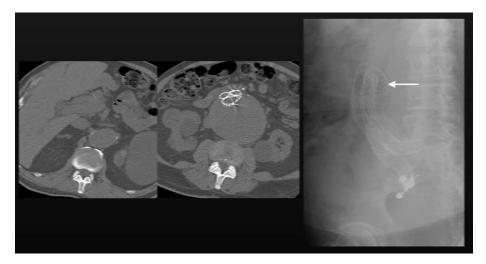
This patient presented 6 years after endovascular repair with an AneuRx device (Medtronic, Inc., Santa Rosa, CA). He had acute limb ischemia from iliac occlusion and a pulsatile aneurysm on physical examination. Computed tomography (CT) scan (left and middle) and abdominal radiograph (right) show the device has migrated out of the proximal neck and kinked (arrow). He had successful conversion and explant.
